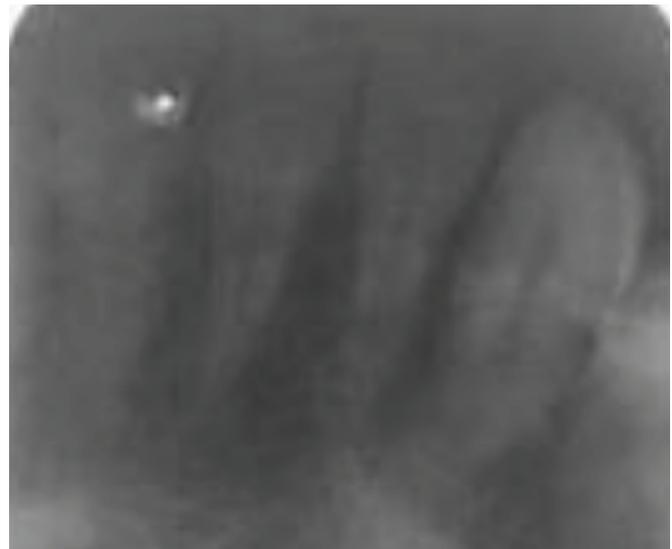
Intraoral periapical – 41, 42, 43
